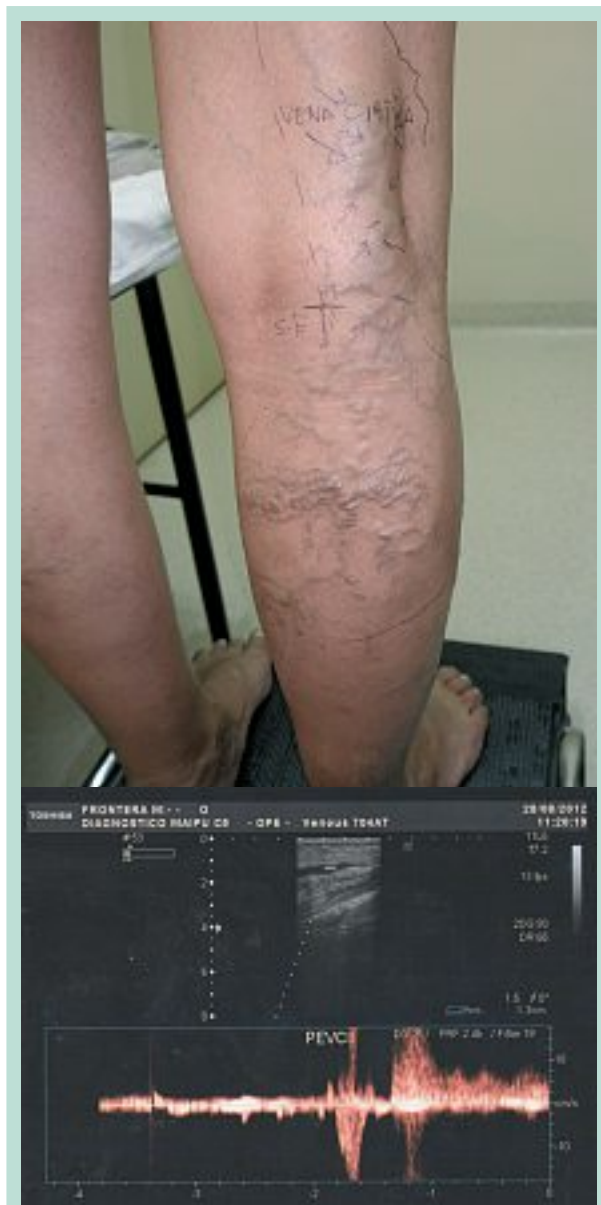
Clinical manifestation and Doppler ultrasound study in a patient with varicose veins of the sciatic nerve during pregnancy.
